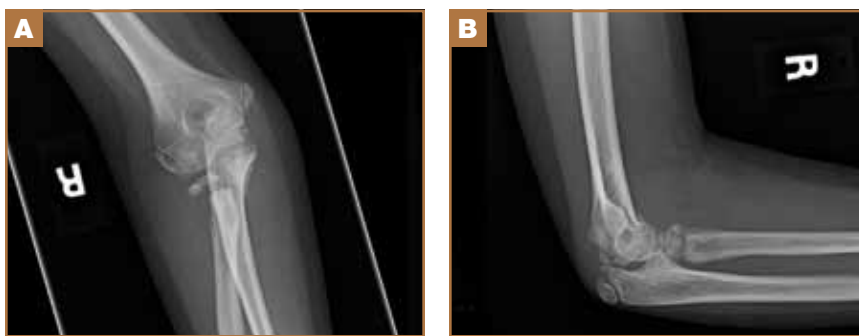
Anteroposterior (A) and lateral (B) radiographic images show interval subluxation of proximal radial epiphysis.
